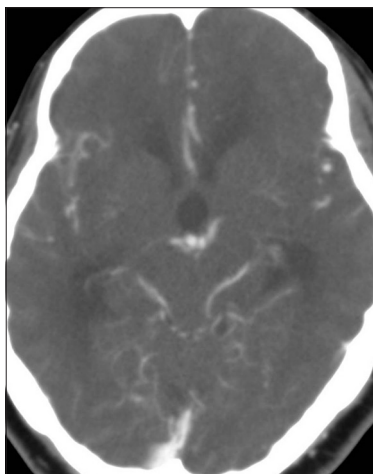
Axial Maximum Intensity Projection (MIP) image of a CT angiogram showing dilation of the frontal and temporal horns of the lateral ventricle and the anterior third ventricle (white arrow). The basilar bifurcation (black arrow) is seen at the posterior end of the third ventricle
